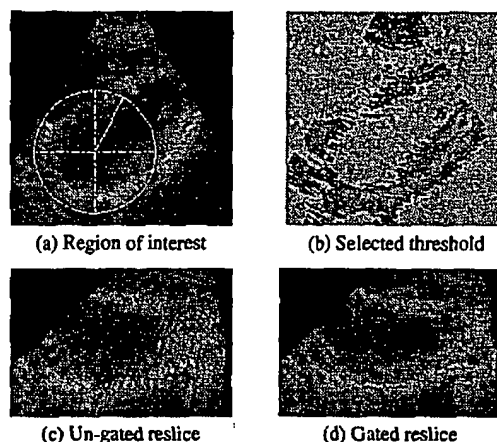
Grey-scale gating in echocardiographic data. The region of interest in (a) and threshold in (b) have been used to gate a cardiac data set. A reslice through one of the ventricles (c) is dramatically improved by gating (d).
